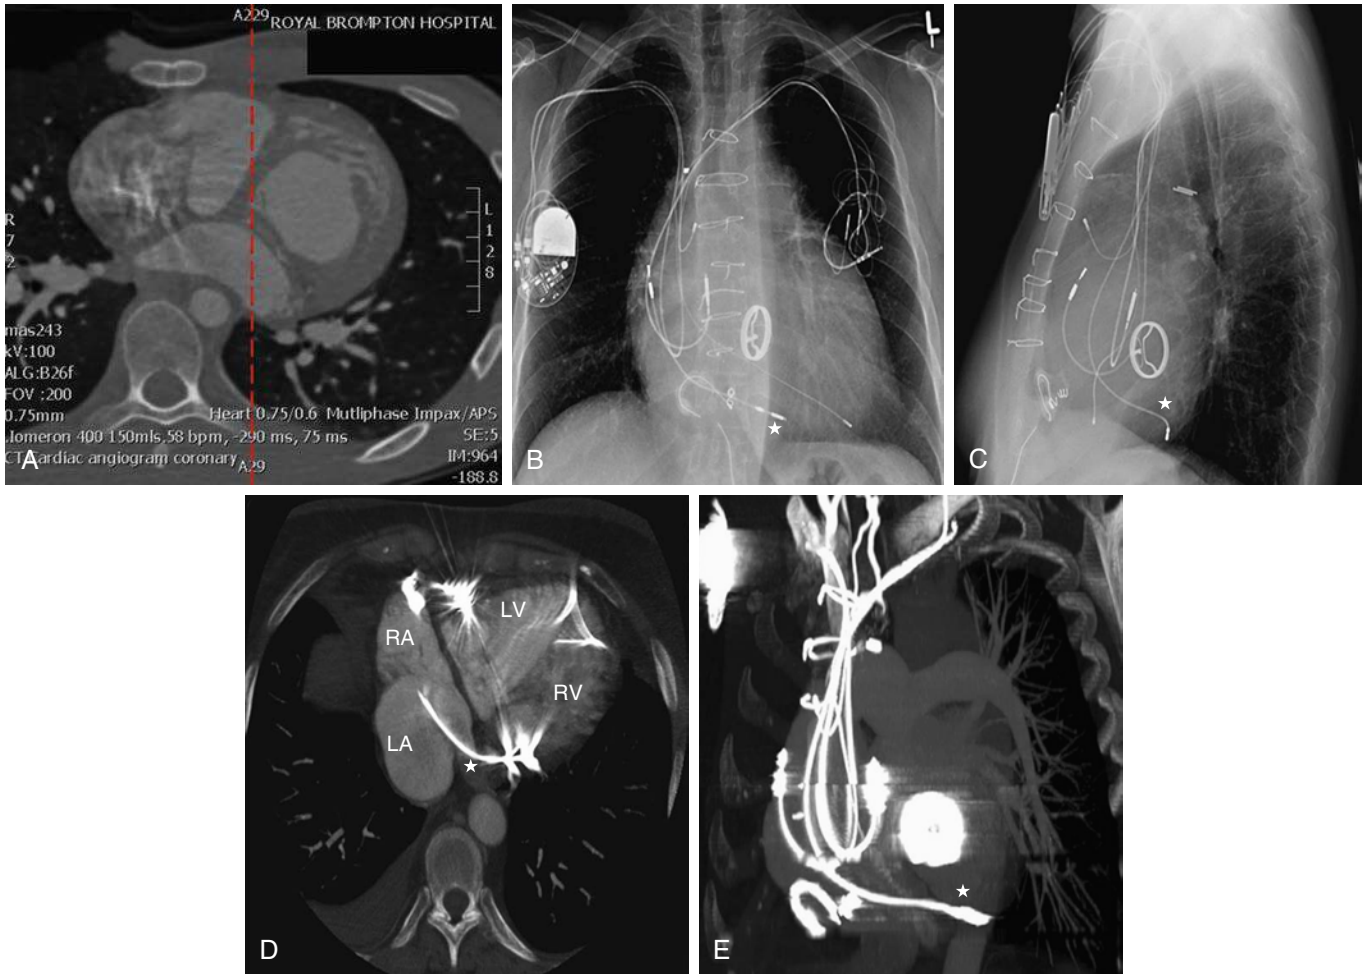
A, Computed tomography (CT) scan of a patient with congenitally corrected transposition of the great arteries (CCTGA) and levocardia. Note the interventricular septum lies close to the anteroposterior plane (red line), so a ventricular lead placed in the anatomic right ventricle may not curve very much to the left, compared to a patient with normal atrioventricular (AV) and VA connections. B to E, A different patient with CCTGA, mechanical systemic AV valve, multiple nonfunctioning leads and a recent upgrade from a dual-chamber pacemaker to a CRT. The functional ventricular lead (★) was believed to be sited in the subpulmonic ventricle, but a lateral chest X-ray shows it takes an unexpectedly posterior course. CT confirms that this lead was actually inadvertently placed into a ventricular branch of the coronary sinus. (Case courtesy Dr. K. Viswanathan.)
